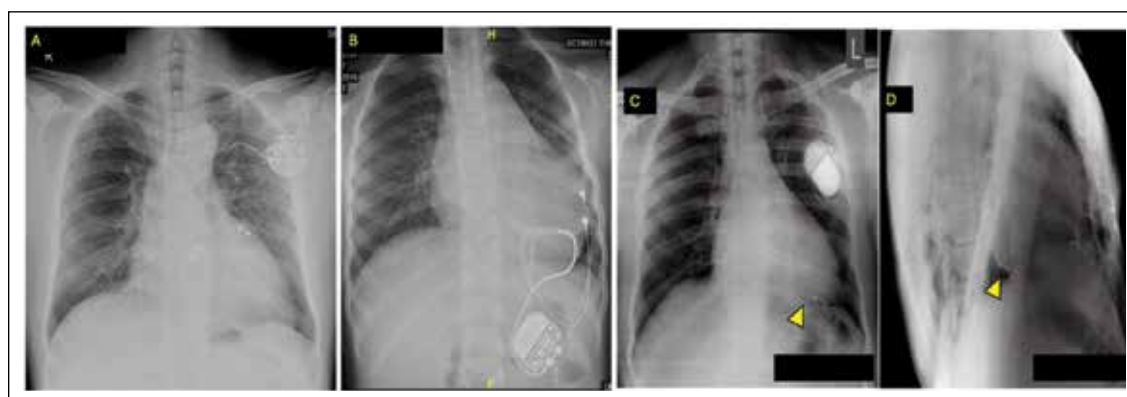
Figure shows different modalities of LV pacing. Patient A is a case of severe AS with mild LV dysfunction and LBBB, perioperatively developed transient CHB. Hence, an epicardial LV lead was inserted to convert to CRT-P later. But the patient improved after a few weeks of discharge and currently $V_p < 1\%$ with incomplete LBBB. Hence, CRT-P was not contemplated. LV dysfunction improved after AVR. Epicardial LV pacing with a pulse generator in the left infraclavicular subcutaneous plane can be seen (A). Patient B is a newborn who was diagnosed with severe coarctation of the aorta, and CHB underwent surgical repair and epicardial pacing for CHB with a pulse generator over the abdominal wall. Patient C is a case of severe RV endomyocardial fibrosis and AF with CHB. As there is no RV body and apex, pacing was done with a bipolar LV lead inserted into one of the epicardial coronary venous tributaries and connected to a single-chamber VVI pulse generator. Frontal chest radiograph (C) and lateral film (D) show the position of the LV lead (arrowhead).
